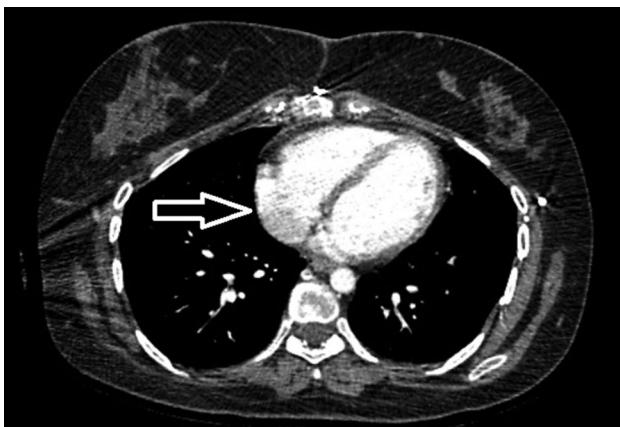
Postoperative computed tomography angiography image of the normal right atrium.
